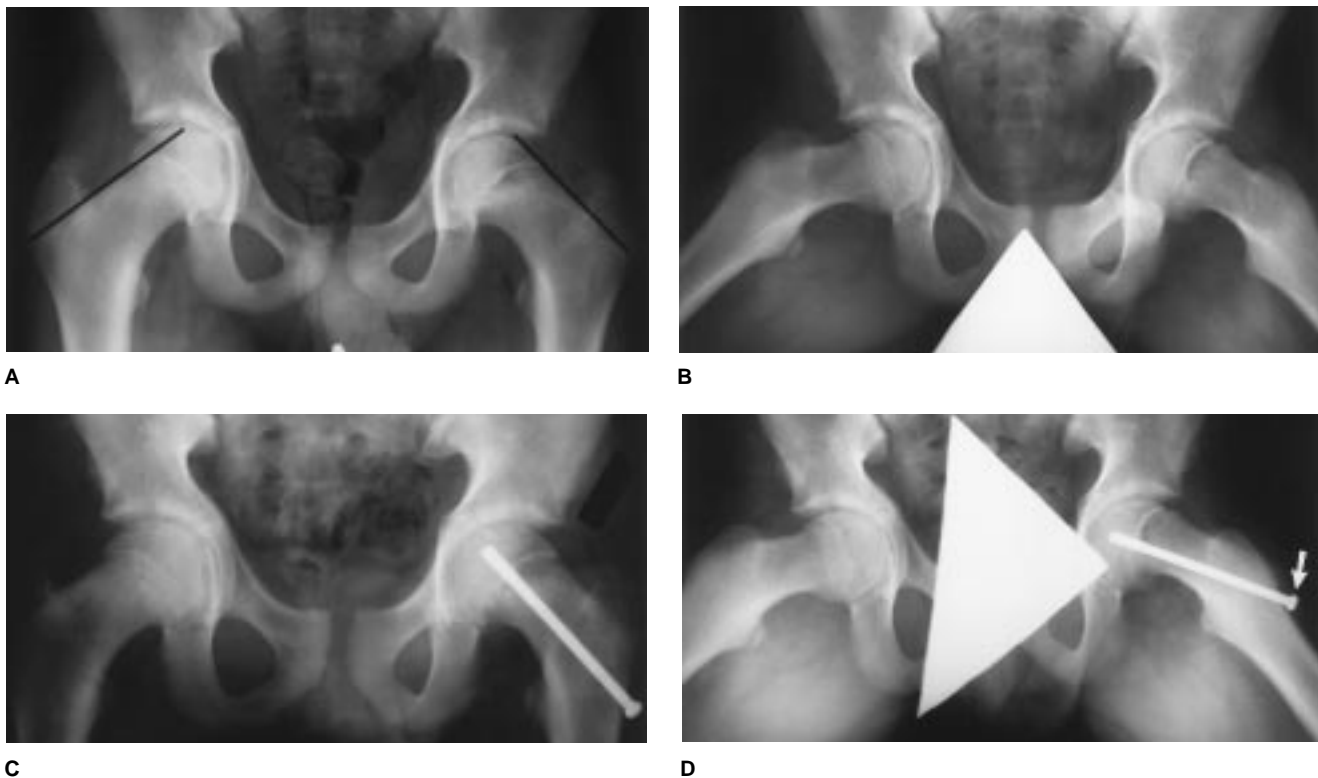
A, Anteroposterior pelvis radiograph of a 12-year-old boy with a stable SCFE on the left. Note that Klein's line fails to intersect the epiphysis on the left. B, Improved visualization of the SCFE on a frog-leg lateral radiograph. C, Postoperative anteroposterior radiograph shows the screw in the center of the epiphysis, perpendicular to the physis. D, Postoperative frog-leg lateral radiograph shows the screw entering the bone anteriorly (arrow), traversing the neck to engage the center of the epiphysis perpendicular to the physis.
